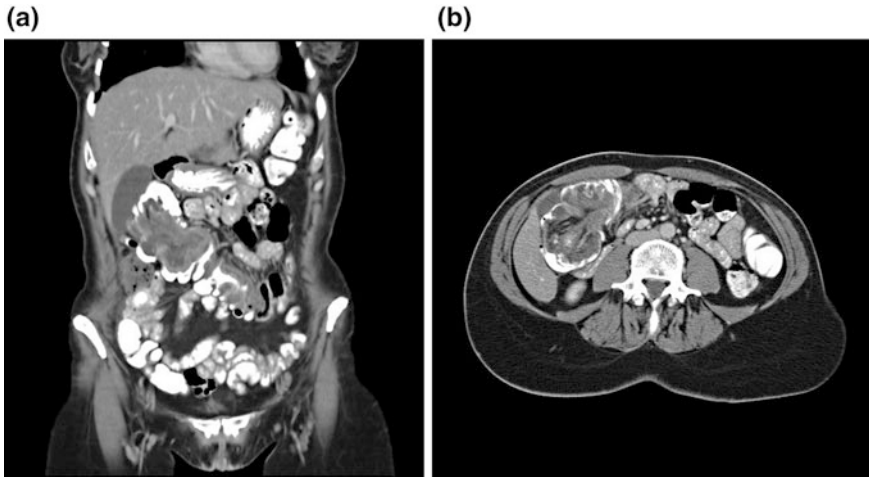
a, b Intussusception on CT scan. © Dale Dangleben, MD
